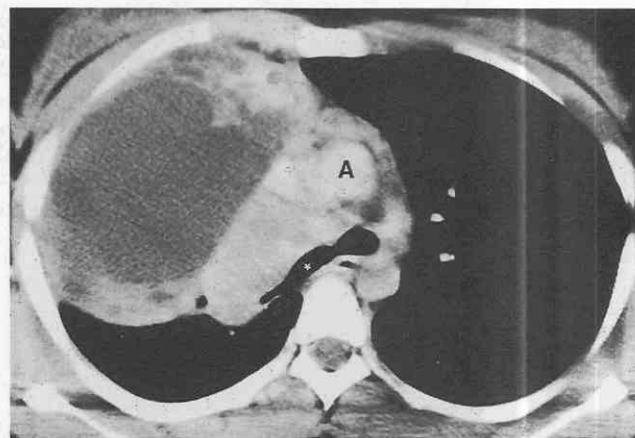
Hodgkin's lymphoma. Contrast-enhanced CT shows an anterior mediastinal mass with a large cystic component. The asterisk indicates posterior displacement of the right main bronchus. A, ascending aorta.
